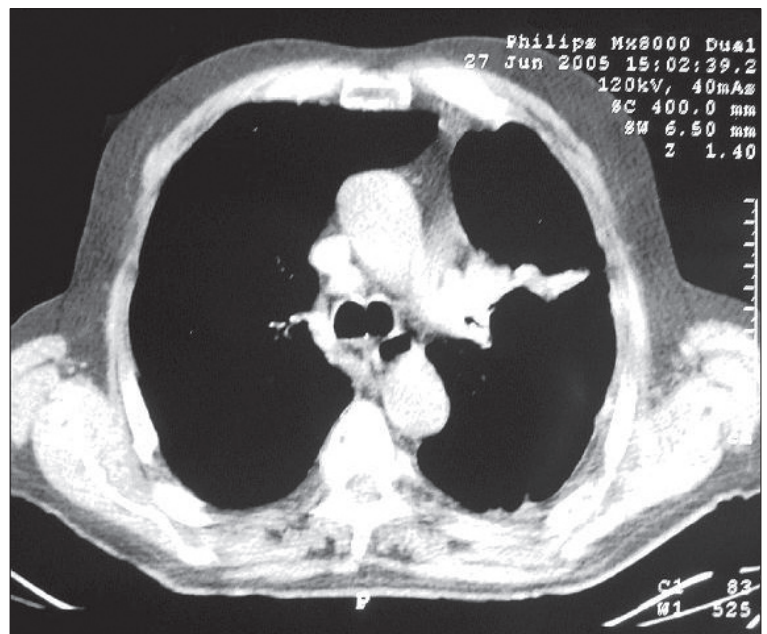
Thorax CT scan showing a soft tissue density obstructing left upper lobe bronchus and segmental atelectasis distal to the density.
